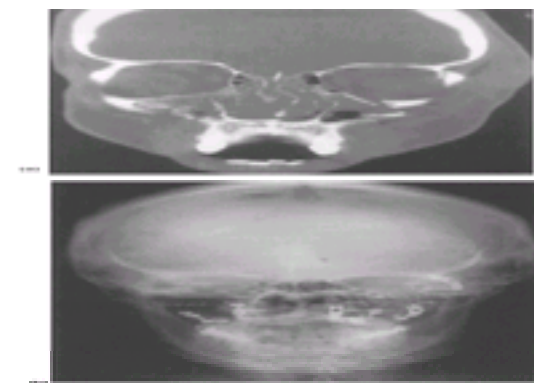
(a) Coronal CT scan showing a complex LeFort fracture of the facial skeleton before reduction; (b) plain radiograph showing miniplates at each of the four maxillary buttresses in a complex midface fracture after reduction and fixation.
